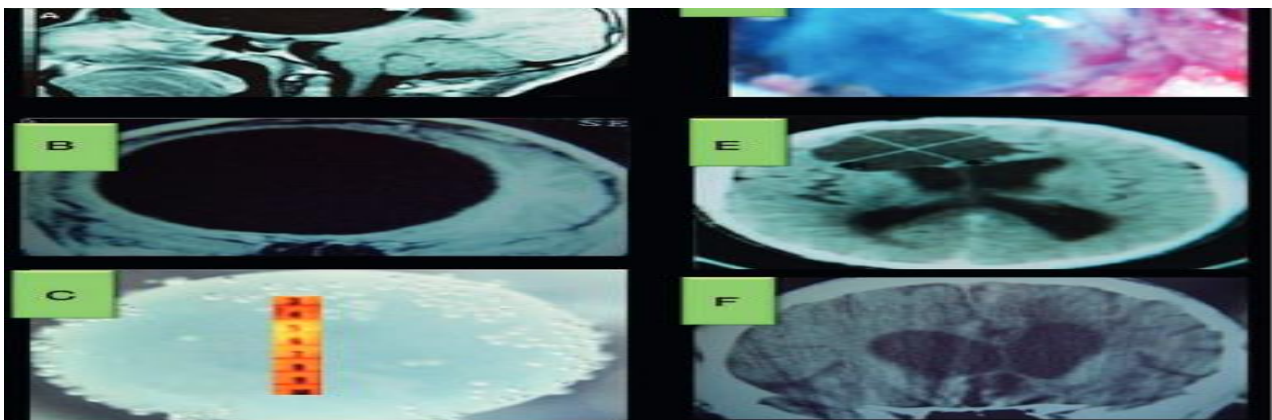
A huge hypointense cystic mass located in the ontotemporoparietal region. The lesion compressed the brain ventricles, anietal, frontal lobes, and also brainstem (A, T1-WMRD); frontal, temporal, and occipital lobes with lateral ventricles and contralateral hemisphere (B, T2-WMRD). The cyst was delivered as intact (C). Inserted water-filled balloon is seen (D), cyst cavity after balloon drawn from brain (E) and 2 years follow-up computed tomography appearance (F).
